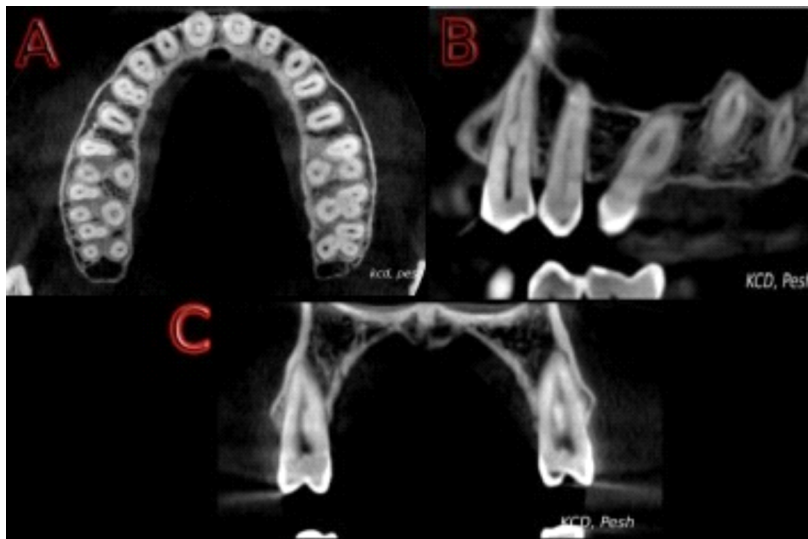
Cone-beam computed tomography radiographic sections: A, coronal view of the maxilla. B, Axial view C, Sagittal view
